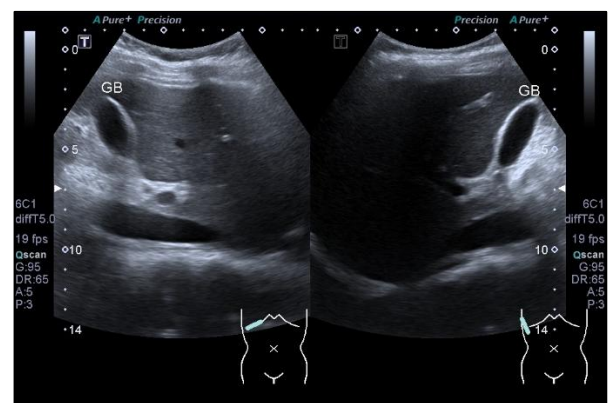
FAST ultrasound shows the presence of free fluid.
